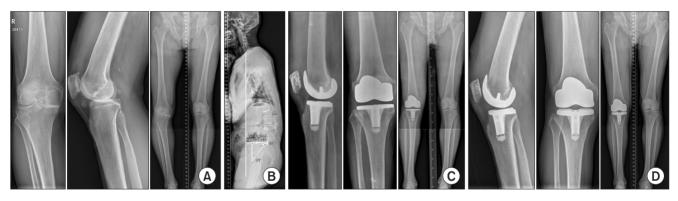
A patient with recurrent flexion contracture after full correction of preoperative flexion contracture during total knee arthroplasty (TKA). (A) Preoperative radiograph. Unilateral TKA was performed in a 75-year-old man with lumbar degenerative kyphosis and preoperative flexion contracture of 20°. (B) Spinopelvic parameters on the standing lateral radiographs: pelvic tilt, 34.8°; pelvic incidence–lumbar lordosis, 50.9°; C7 sagittal vertical axis, 11.4 cm. (C) One-week postoperative radiographs showing no residual flexion contracture after TKA. (D) Two-year postoperative radiographs showing recurrent flexion contracture after TKA.
